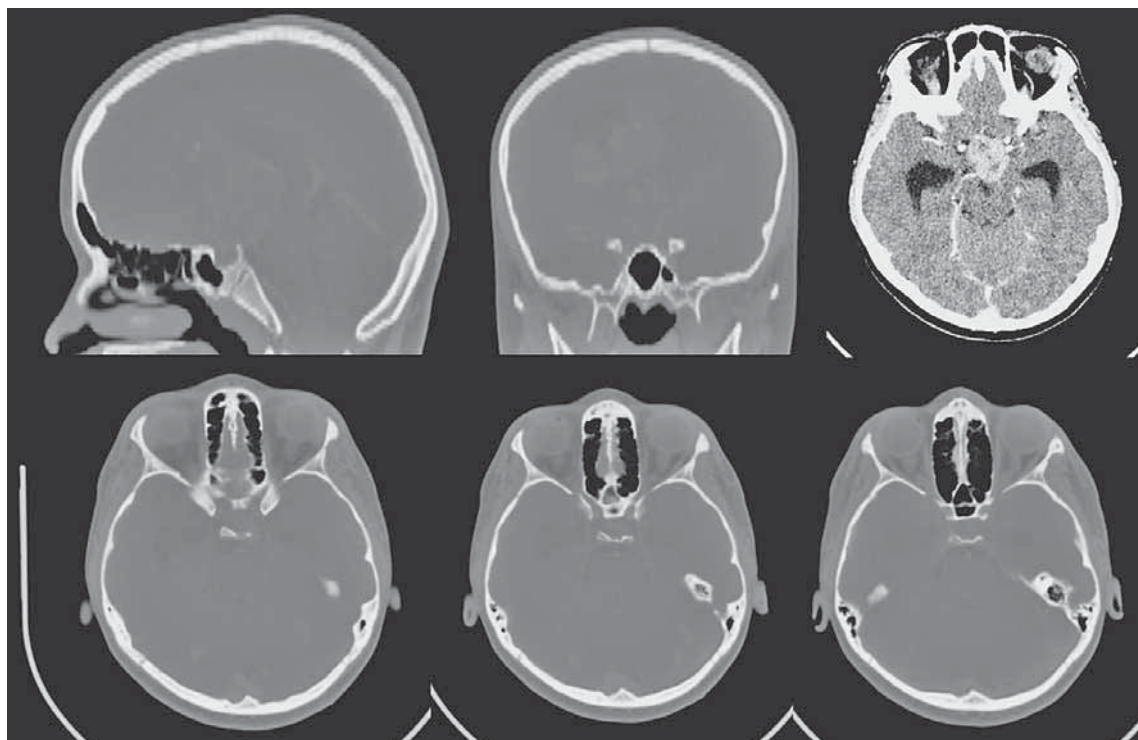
CT scan showing a large mass located in the third ventricle, measuring 6.3x5.0 cm, with supra- and retrosellar extension and no bone erosion.
